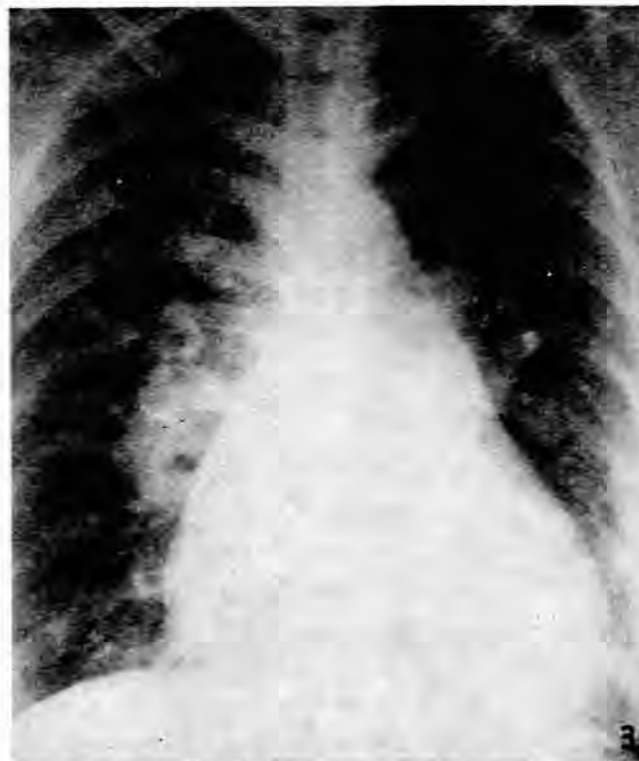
Posterior-anterior radiograph showing enlargement of right atrium, both main pulmonary arteries, and right ventricle.
